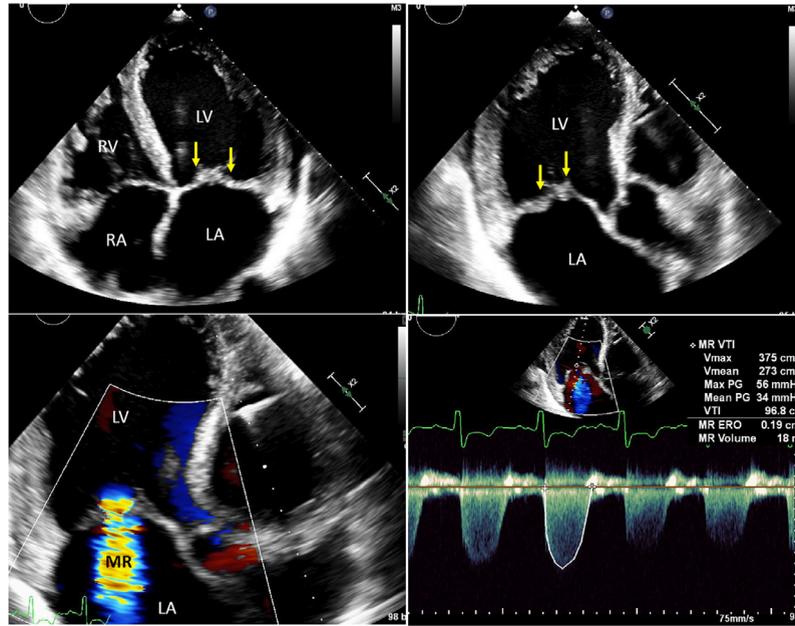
Top left:* Apical 4-chamber view at end-systole showing 4-chamber dilation with thickened mitral leaflets (arrows) that never prolapsed into the left atrium (LA). The LA is bowed toward the right atrium (RA) consistent with high LA pressure. RV = right ventricle. *Top right:* Apical long-axis view showing thickened mitral leaflets (arrows) without prolapse. *Bottom left:* Apical long-axis view of centrally directed mitral regurgitation (MR) jet. *Bottom right:* Continuous wave doppler of the MR jet showing a low peak velocity – 3.75 m/s, suggesting very elevated LA pressure. The calculated EROA was 0.19 cm², a value suggesting only mild MR.
